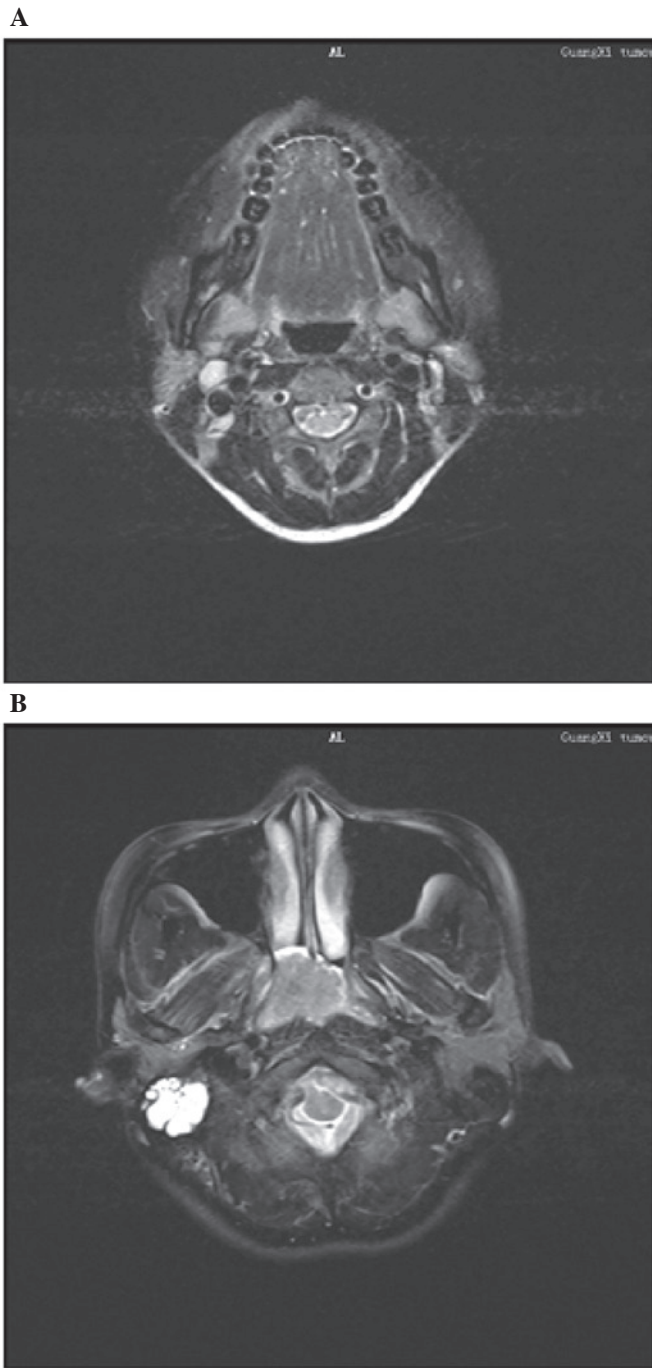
(A) An axial MR image showed an enlarged lymph node with high signal intensity in the right neck region. (B) The enhanced mass had invaded the pharyngeal space. MR, magnetic resonance.
